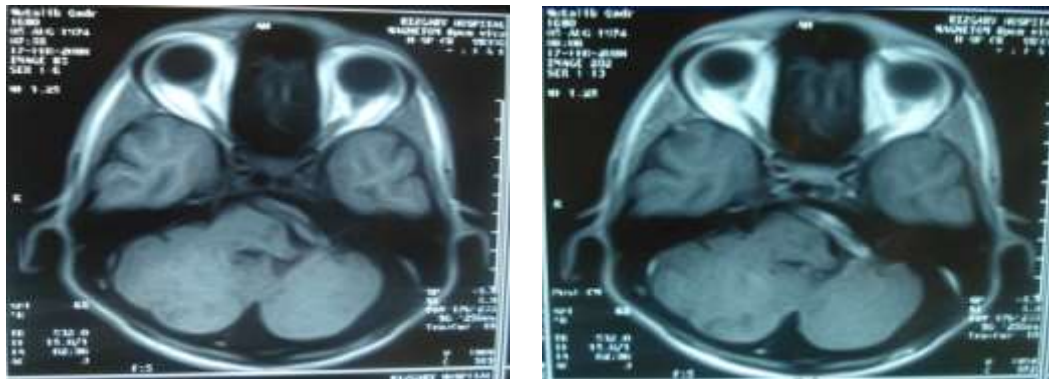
MRI in axial T1WI pre (A) and Post (B) contrast showing thrombosed anomalous vascular shadow traversing left CP angle
